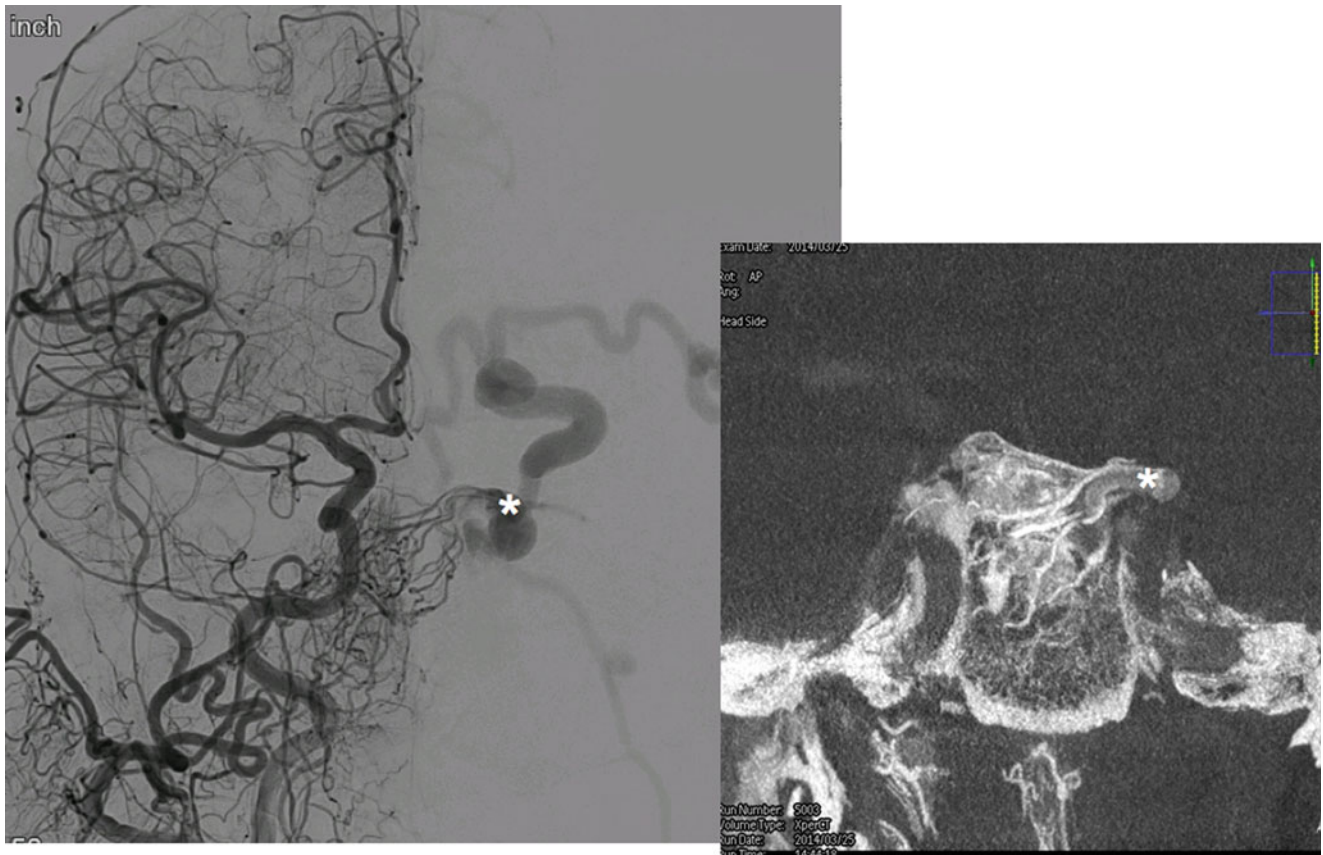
A 67-year-old woman presented with left chemosis and ophthalmoplegia. Right carotid angiography (AP view) and high-resolution cone beam CT (*left*) showing carotid cavernous
